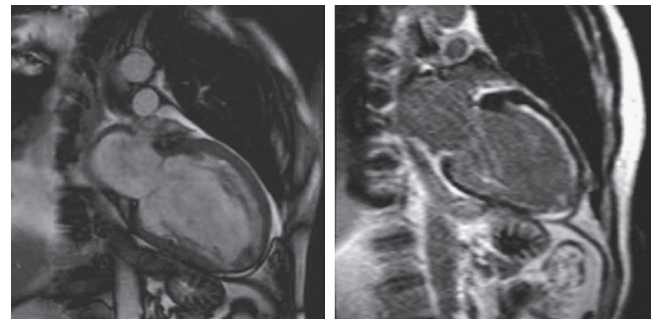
■ Cardiac magnetic resonance images with late gadolinium enhancement. *Left*, Normal subject, without myocardial scar. *Right*, An example of extensive transmural myocardial scar in a patient who will undergo surgical left ventricular restoration. The two-chamber view is shown. Note the bright myocardium extending from the basal anterior region to the apex and inferoapical region.
